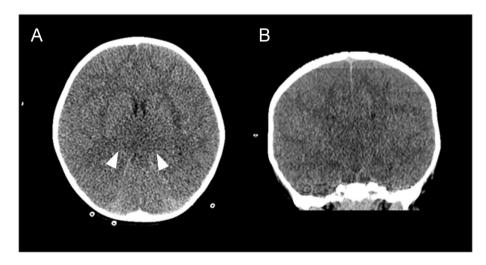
Brain CT of Case 1. Axial (A) and coronal (B) non-contrast CT shows low attenuation in the bilateral thalamus (arrowhead) and diffuse effacement of the sulci and lateral ventricles, indicating diffuse cerebral edema.
